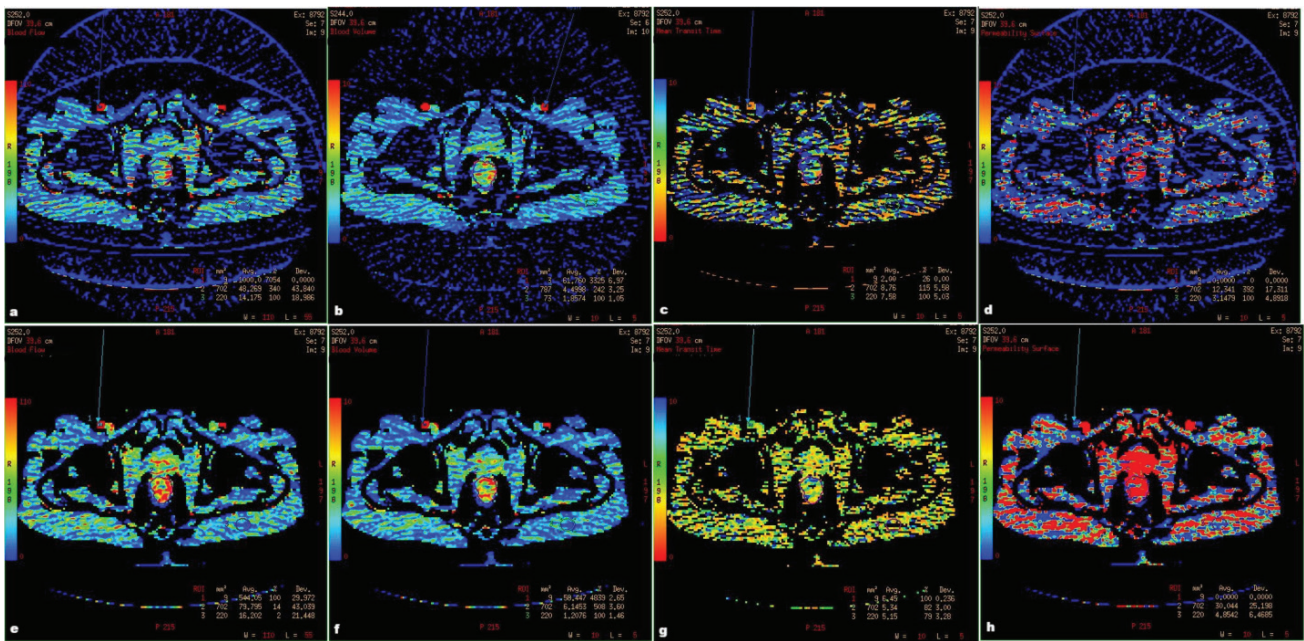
CT perfusion parameter values (BF, BV, MTT and PS) of the same tumor of the rectum (adenocarcinoma) after the neoadjuvant chemo-radiotherapy (violet) and neighboring skeletal muscle (green), obtained by two versions of the deconvolution-based commercial CT perfusion software: (a-d) GE Perfusion 3.0 (e-h) GE Perfusion 4.0 (Images are author's work and written informed consent for publishing their anonymous images was obtained from a patient)
